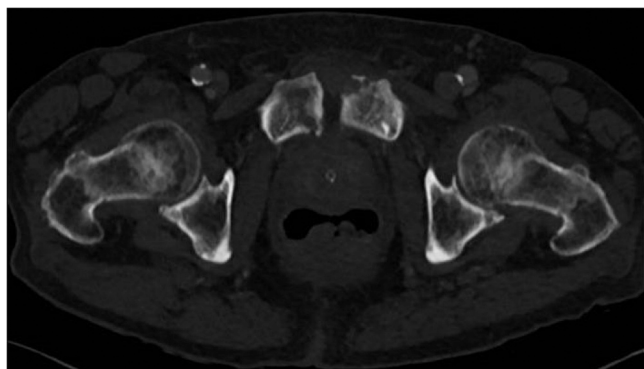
Favorable evolution of symphysis osteomyelitis on a CT-scan performed two months after antimicrobial therapy initiation.
